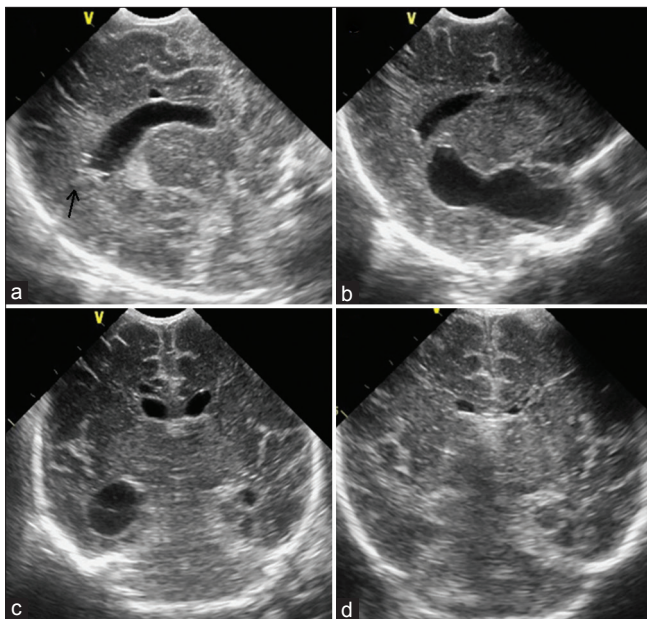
Sonography image of case 1 after the insertion of the second external ventricular drainage tube showing external ventricular drainage (arrow) in the trigone of the left ventricle, and a previous removed external ventricular drainage tract in the left frontal periventricular region (a). Trapped temporal horn of the left lateral ventricle (b and c) was detected 11 days later. Follow-up sonography after the third external ventricular drainage tube insertion revealed normal-sized ventricles (d)
